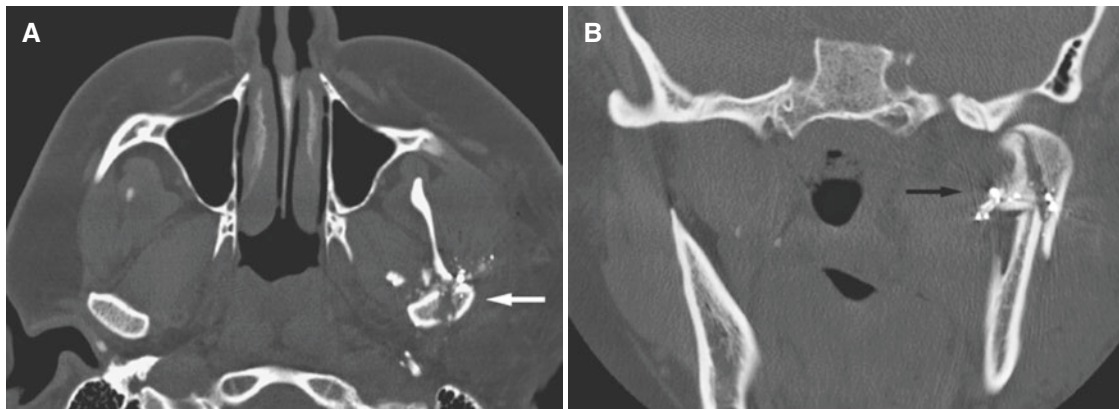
Mandibular condyle fracture, comminuted; 23-year-old female with gunshot to the face. (A) Axial CT image shows multiple bone and metallic fragments and intracapsular condyle fracture (*arrow*).
